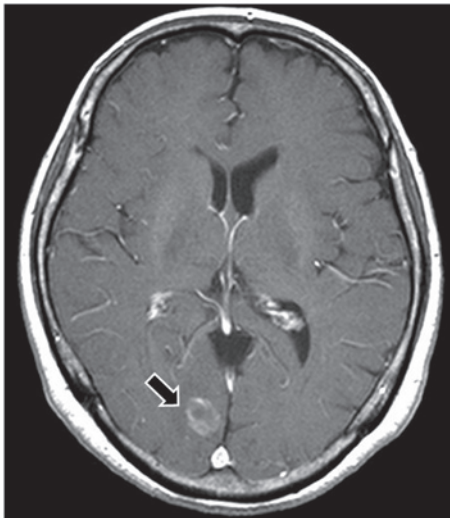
Follow-up brain magnetic resonance imaging, performed 24 months after the surgery, detected a cerebellar metastasis (arrow).
